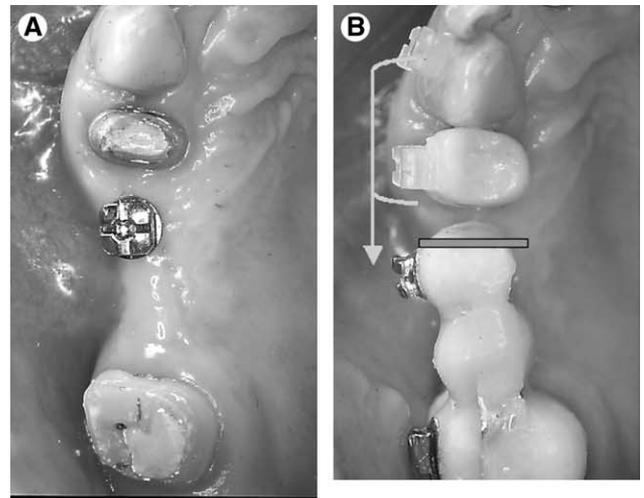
Temporary bridge anchored to Spider Screw®. (A) Maxillary occlusal with bridge removed. (B) Maxillary occlusal with new temporary bridge. (C) Right buccal. (D) Maxillary occlusal. (E) Bite-wing x-ray.
